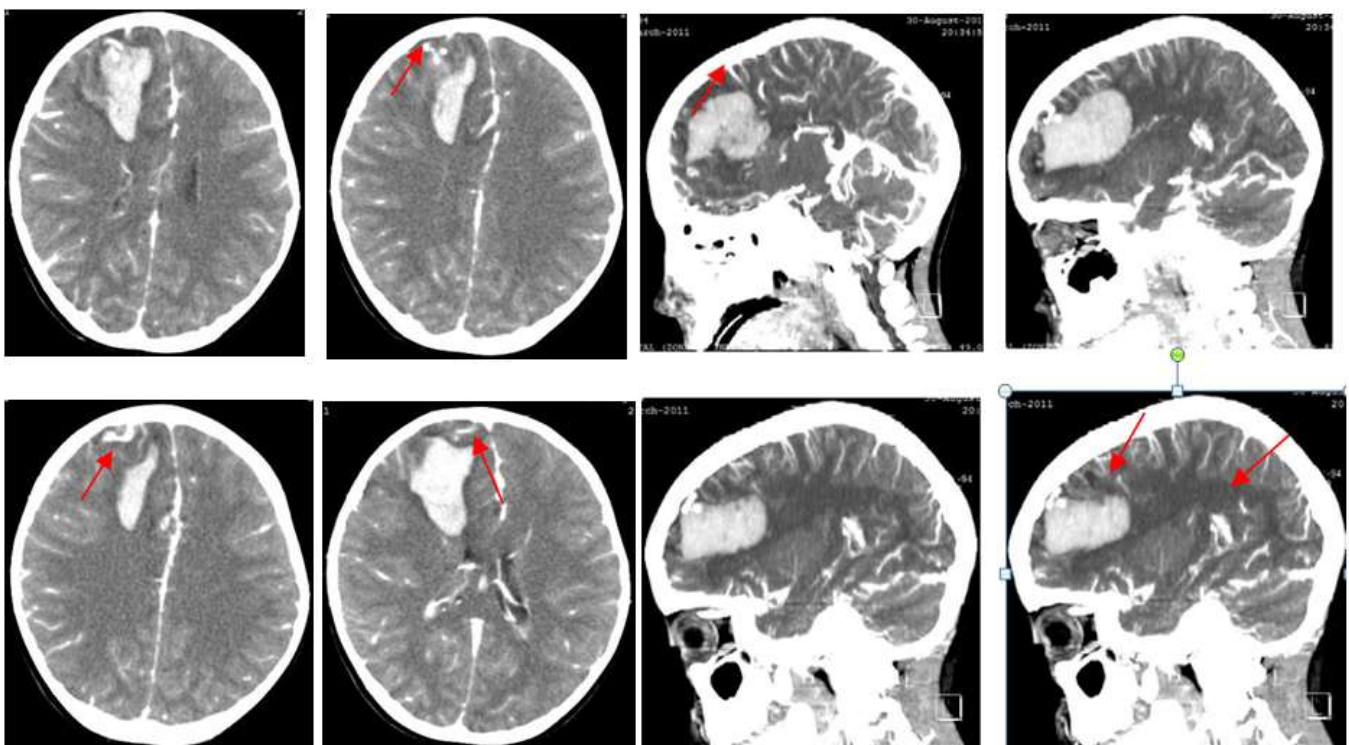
A. Cranial angio-CT scan (Axial). B.Cranial angio-CT scan (Sagittal).
